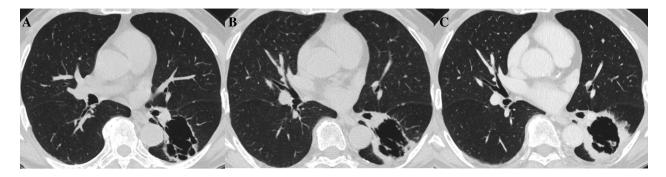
Chest computed tomography images acquired 12 (A) and six (B) months before, and during (C) admission. Cancer has progressed along the wall of cyst in left lower lobe.
